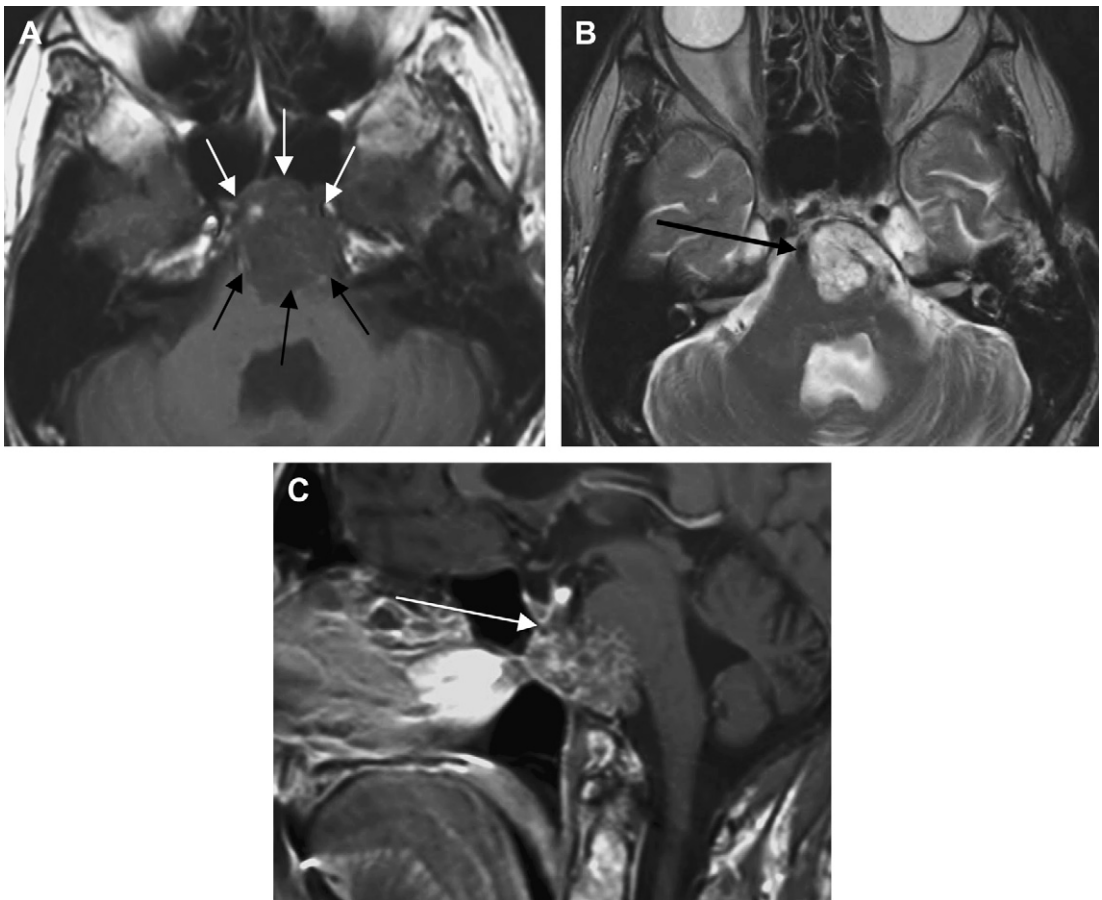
Axial T1-weighted (A), T2-weighted (B), and gadolinium-enhanced sagittal T1-weighted (C) images show a mass lesion expanding and replacing the fatty marrow of the clivus, with frank destruction of the superior cortical margin. The lesion extends into the posterior cranial fossa, obliterates the prepontine cistern, displaces the basilar artery to the right (*long black arrow in B*), and compresses the ventral pons (*short black arrows in A*). Anteriorly, it bulges into the sphenoid sinus (*small white arrows in A*), and, superiorly, it stops at the sellar floor (*long white arrow in C*). The lesion is of intermediate signal intensity on T1-weighted imaging and hyperintense on T2-weighted imaging, with a faint trabecular pattern, and shows lobulated honeycombed-like enhancement (clival chordoma).
